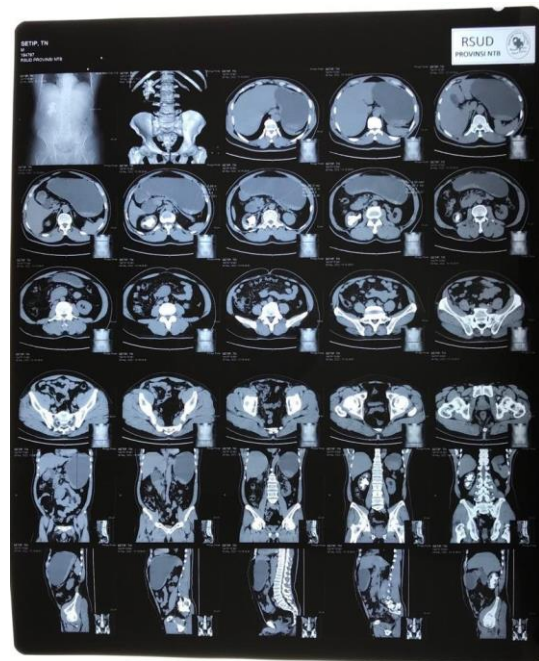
CT Scan Abdomen Non Contrast showed staghorn renal stone dextra 7,5x5cm and no hydronephrosis
